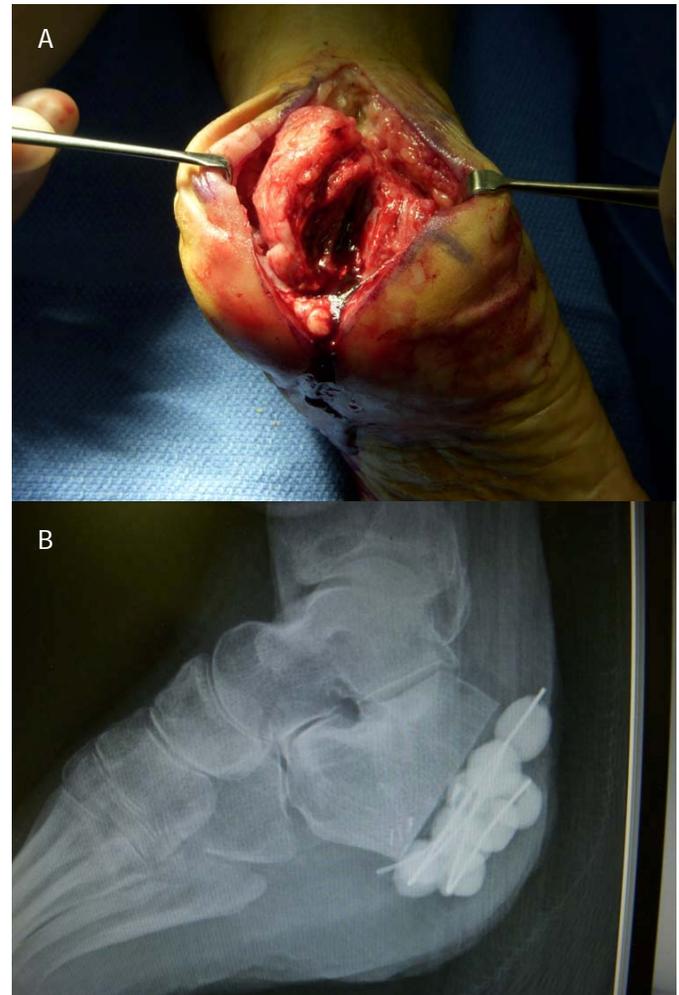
(Patient #2) Intra-operative photo demonstrating the extent of the osseous destruction and depth of the sequestrum. (a) Post-operative radiograph demonstrating the extent of bone resection and antibiotic cement beads. (b)
